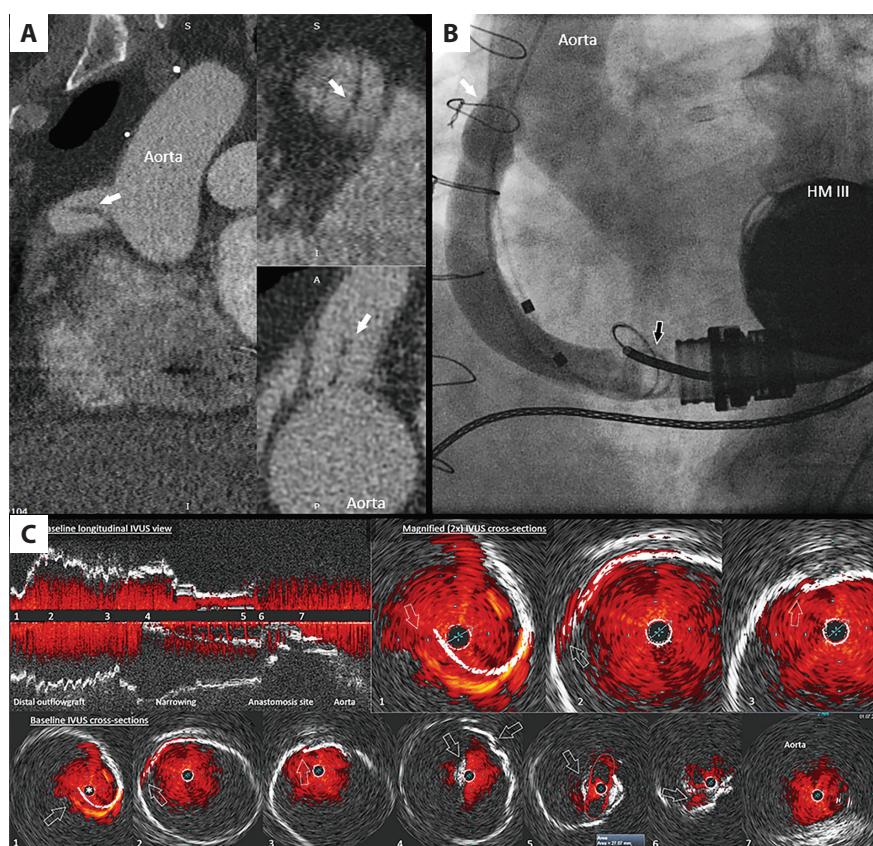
A. Baseline multi-slice angio computed tomography revealing filling defect at the site of the outflow graft anastomosis with the aorta (arrows). B. Corresponding invasive angiography of the entire graft length, with the marked distal position of the pigtail catheter and the anastomosis site (black and white arrows, respectively). C. Baseline IVUS longitudinal view of the distal outflow graft with indicated sites of the relevant cross-sections shown in the lower row (no. 1–7, correspondingly). ChromaFlo documented the presence of a distal pseudo intimal dissection near the left ventricular assist device outflow and a smaller tear in the mid outflow graft segment, not compromising the lumen (cross-sections no. 1 and no. 2, respectively, arrows). The 3rd site of the pseudo intimal dissection in the anastomosis region (cross-section no. 3) gradually increased in its size with a ChromaFlo signal seen on both sites of the occlusive flap (cross-section no. 4) with the lumen cross-sectional area narrowed to 0.28 cm² (cross-section no. 5). The presence of the blood flow in the false channel was also seen at the site of graft insertion into the aorta (cross-section no. 6)
